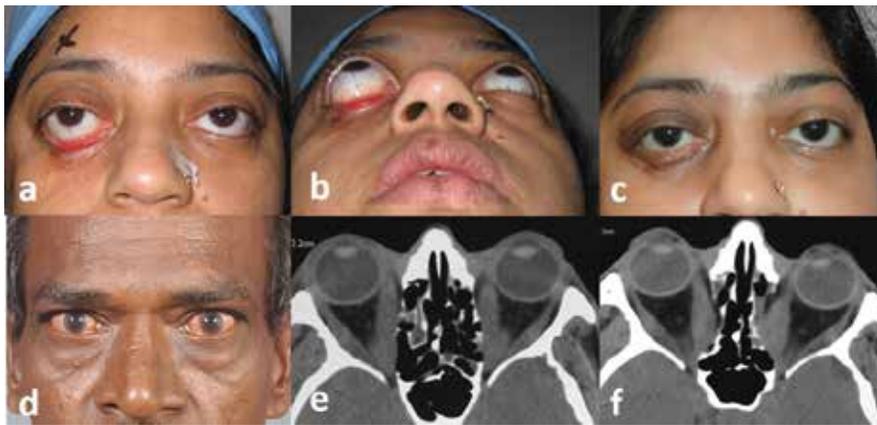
Orbital decompression for thyroid orbitopathy. Right disfiguring proptosis and lower lid ectropion in the quiescent phase of GO in a female patient (Figure 9a,9b). Appearance following deep lateral orbital and fat decompression (Figure 9c). Compressive optic neuropathy due to apical crowding by bulky extraocular muscles as seen on CT scan in a male smoker with TED (Figure 9d, 9e). Reduction in the apical crowding seen on CT scan following endoscopic medial wall decompression (Figure 9f).
